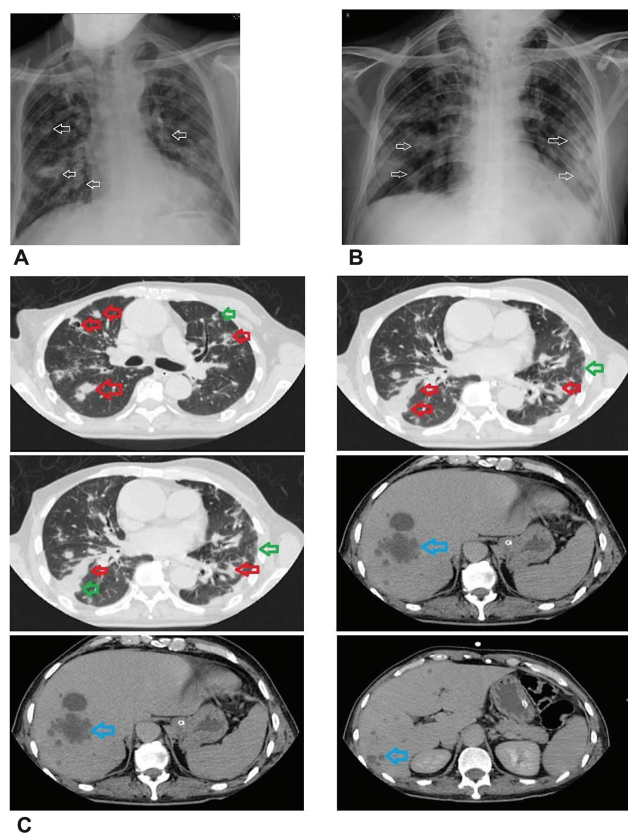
(A) X-ray chest showing a few nodular opacities in both lung fields, maximum in right lower zone suggestive of infective etiology. (B) X-ray chest showing increase in nodular opacities as compared to a prior X ray, features suggestive of worsening of pulmonary infection. (C) Multinodular lesions in bilateral lung fields with cavitations (red arrow) and surrounding ground glass opacities (green arrow) [in top two panels and left middle panel] suggestive of infective etiology more likely to be fungal. Multiple hypodense (blue arrow) hepatic lesions in segments VII and VIII, suggestive of multiple abscesses. [right middle panel and both lower panels].
